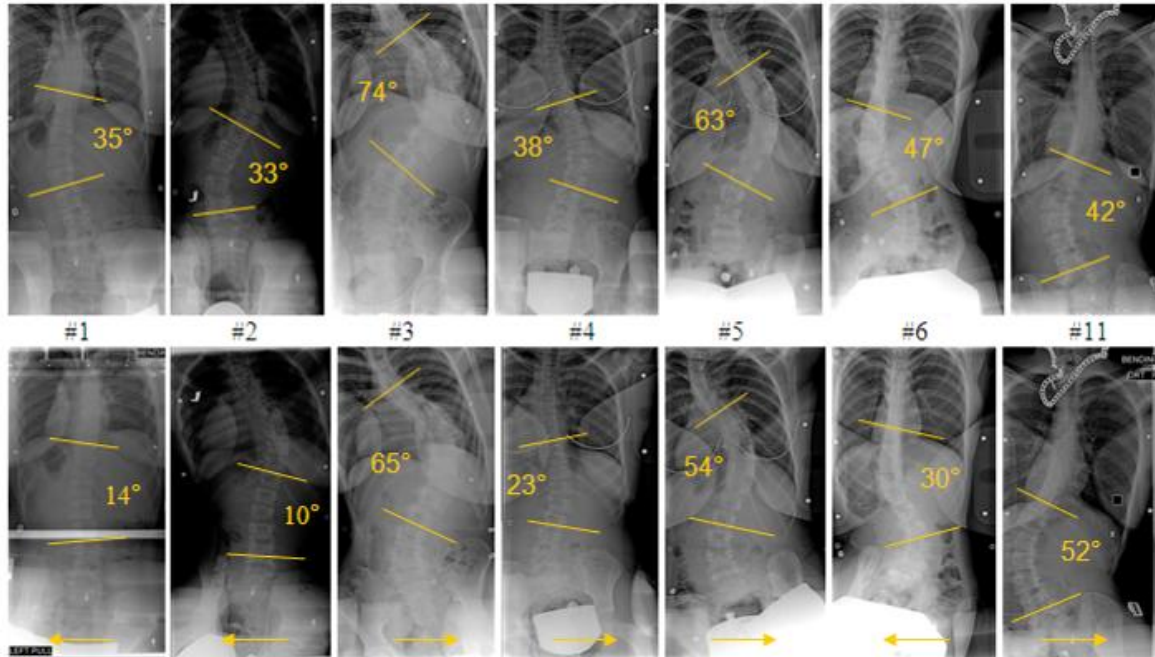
(A4F2): Radiographs of patients 1 to 6 and 11 in the neutral prone (top row) and laterally bent leg (bottom row) positions; arrow indicated direction of lower limb displacement
